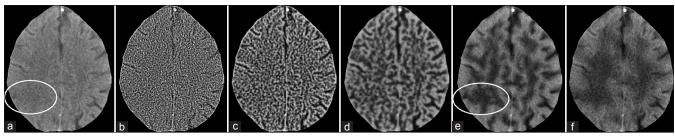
Enhancement of only one specific scale. (a) Original CT image. (b) through (d): Enhancement of error images of scales 1 through 5
